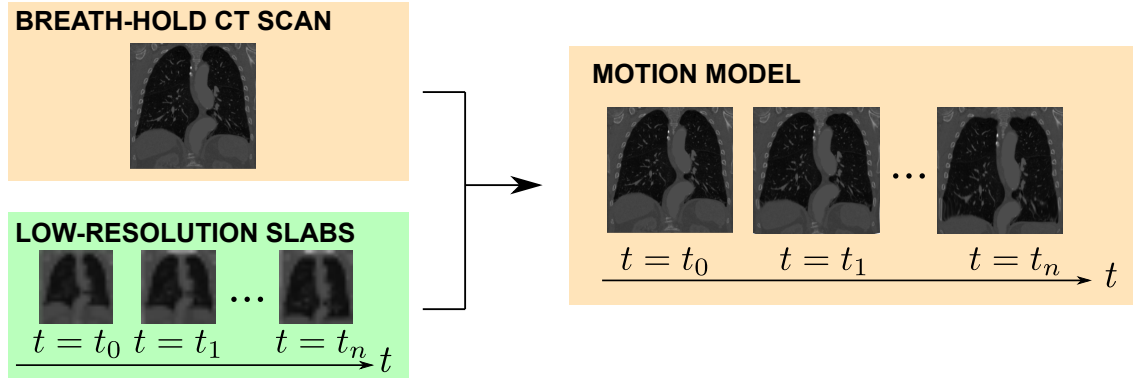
A high-resolution CT scan is non-rigidly registered to each slab of a temporal sequence of continuous low-resolution CT scans. This process yields a temporal sequence of continuous high-resolution CT scans that gives a clear picture of the changes in the anatomy of deformable structures.
